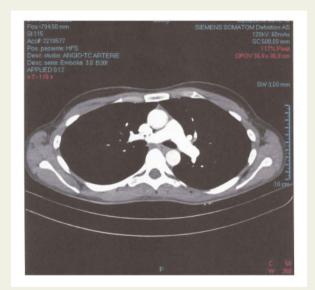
Computed tomography evidence of bilateral subsegmental pulmonary embolism.
